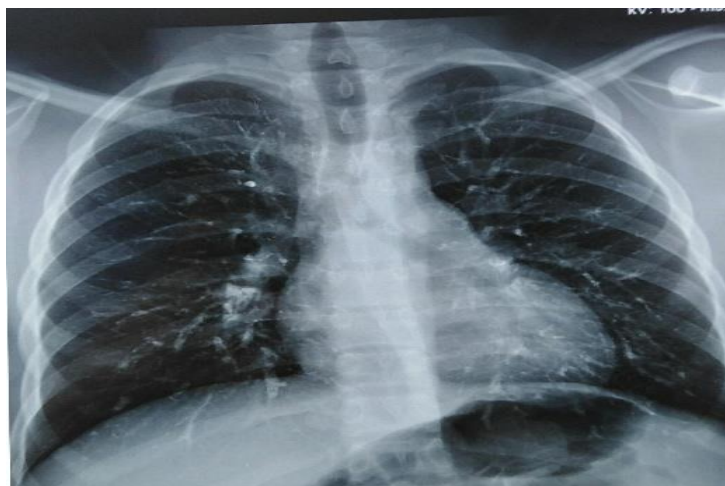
Chest X-ray: The pulmonary vasculature is significantly more prominent and appears to demonstrate intravascular contrast despite a lack of intravenous contrast administration.
